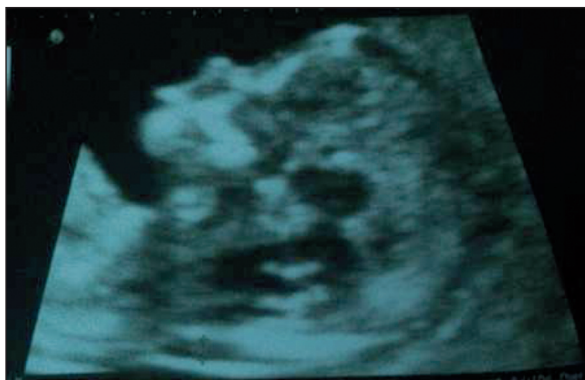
First Trimester Ultrasound assessment.
